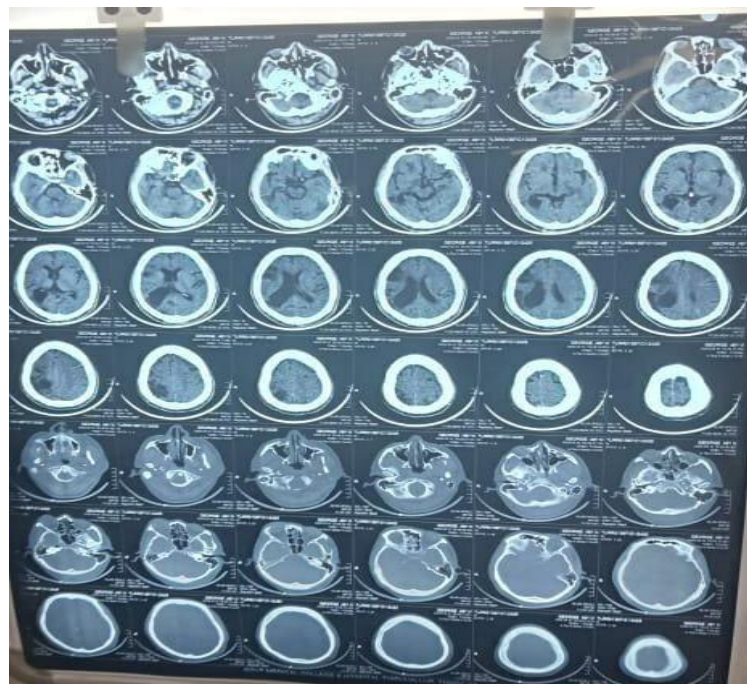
CT BRAIN Showing hypodensity noted in right frontal region likely non hemorrhagic infarct. (Date: 16/04/2024).
